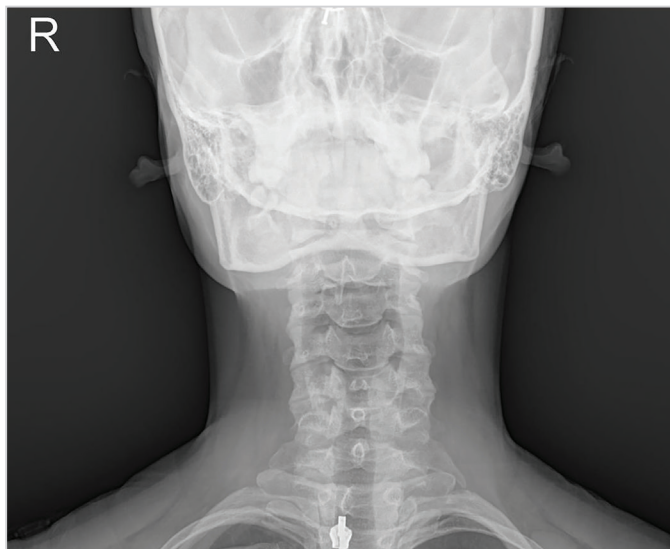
No findings supporting emphysema observed in the cervical radiograph
